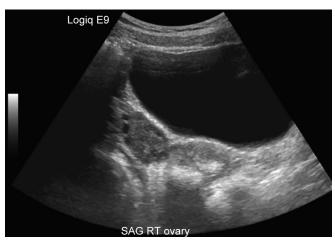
Transabdominal ultrasound of the ovary
